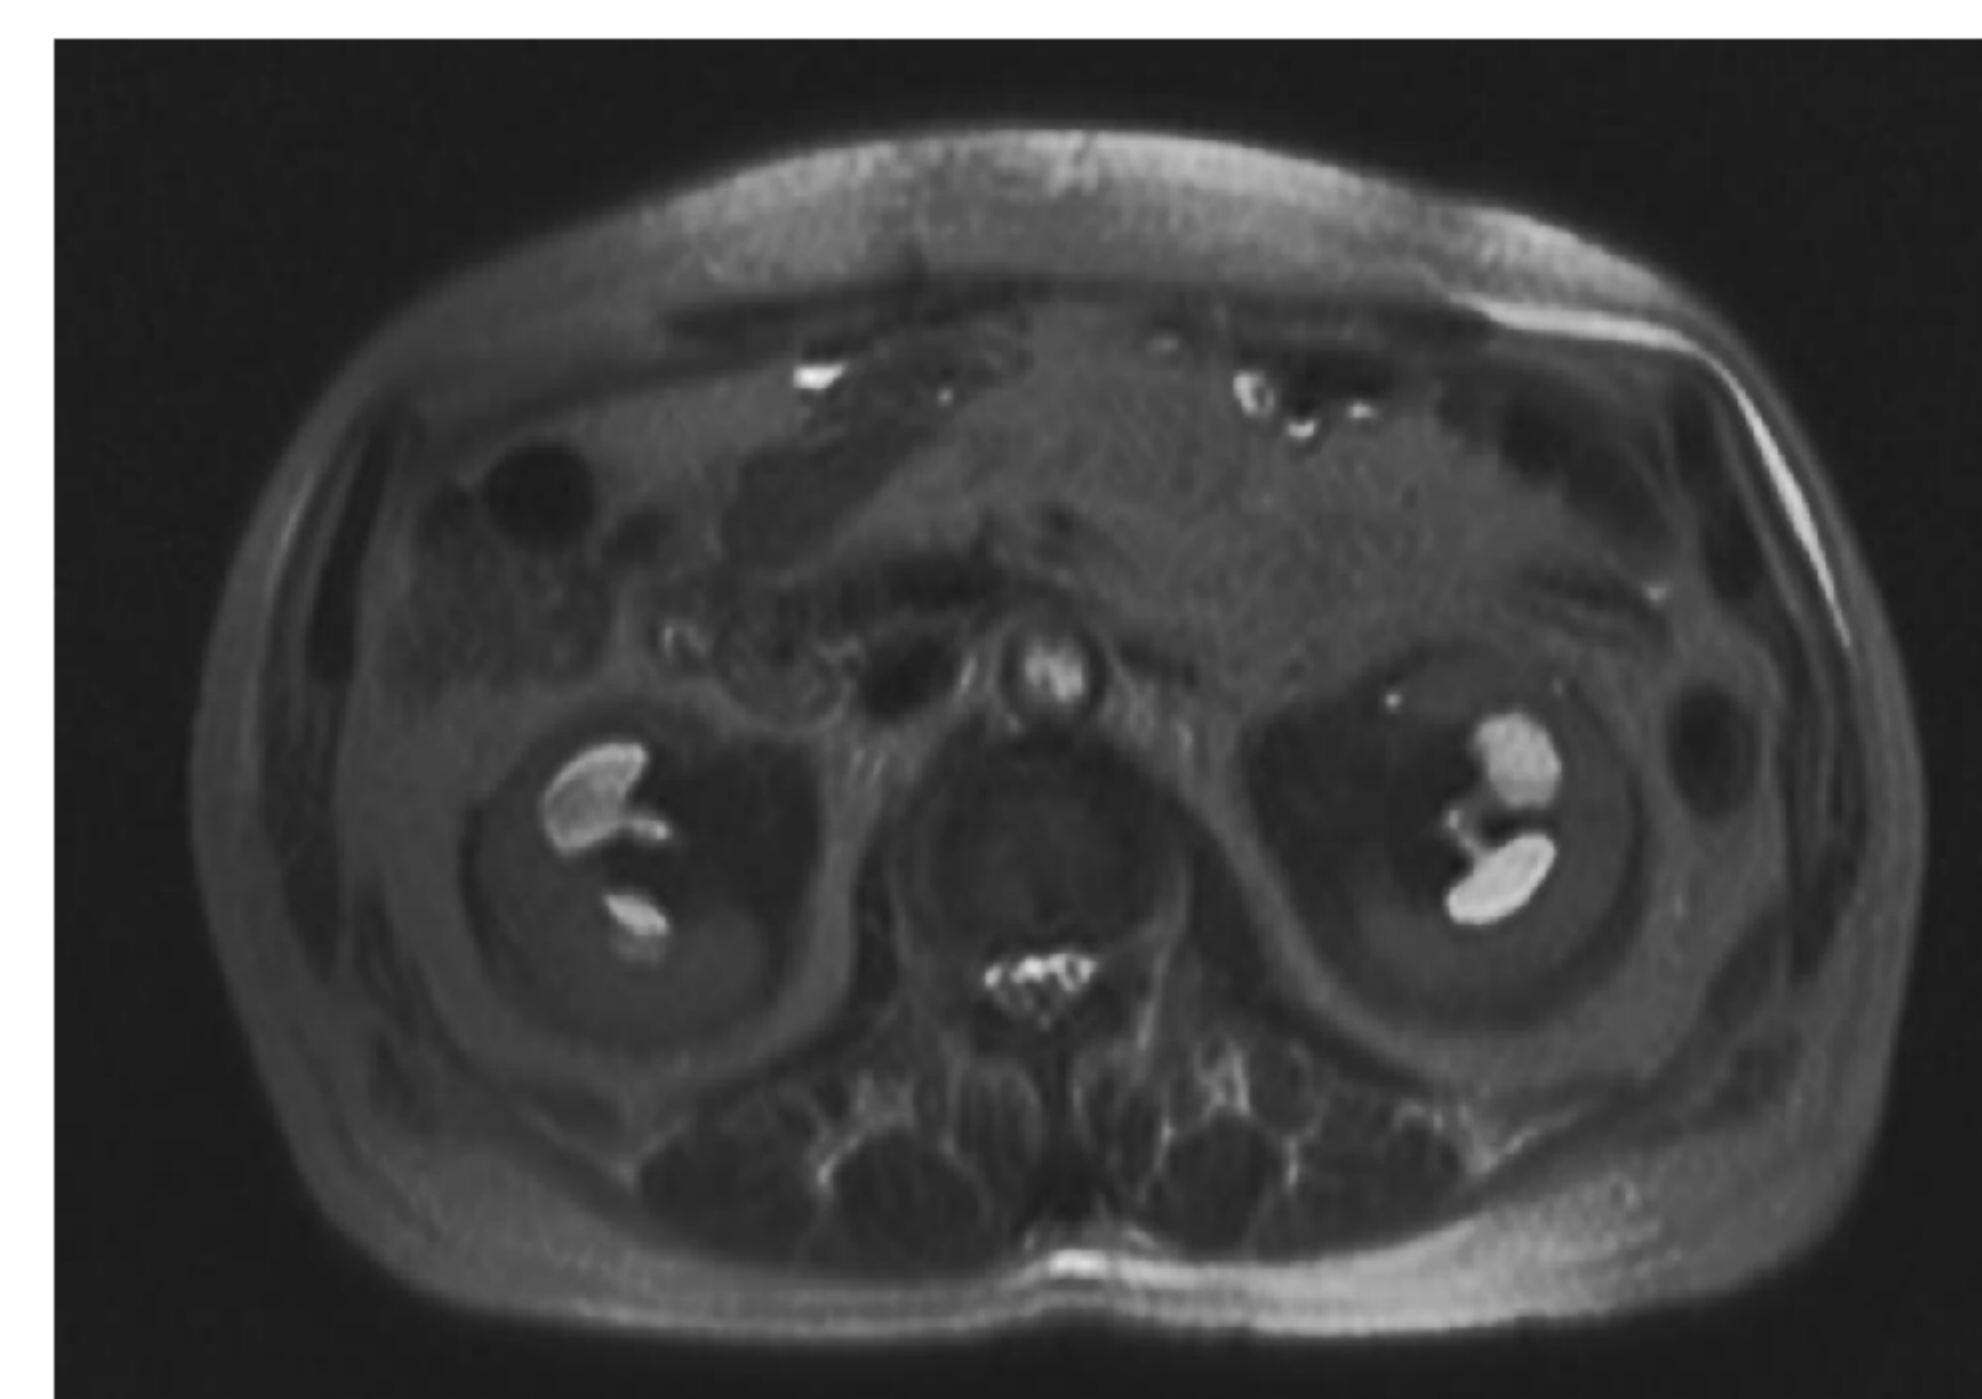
Abdominal T2-Weighted MRI (Trasversal and Coronal Planes)
